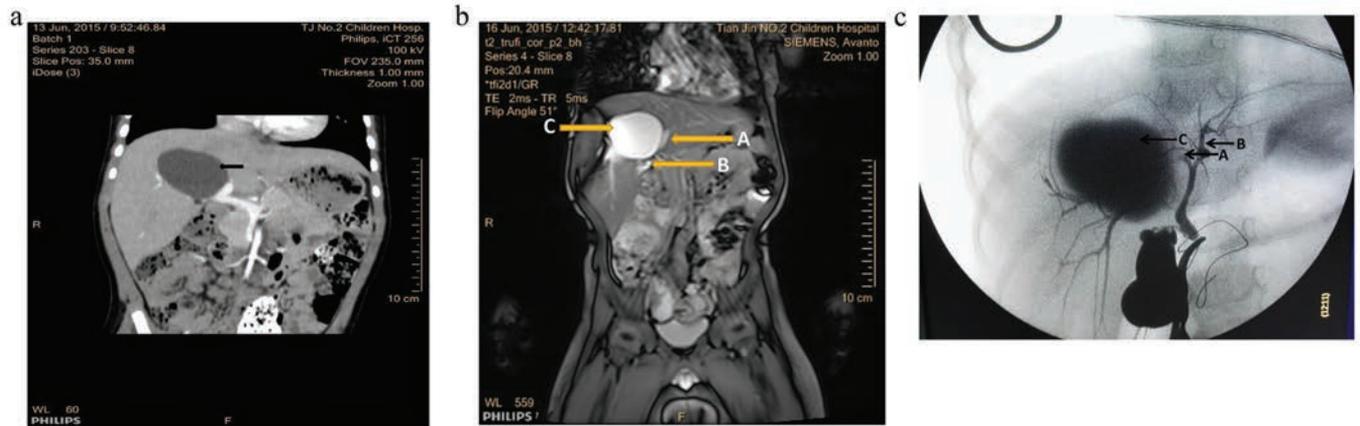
a: CT scan (arrow) shows cystic mass in the right hepatic lobe, the mass boundary is irregular, the size is about 54.1 * 48.6 mm, extending to the hepatic hilar region. Fig. 1b: MRI showing an irregular mass in the right hepatic lobe, which is about 5.1_4.6_4.3 cm, the border is clear. Adjacent intrahepatic duct is lightly pressed, the mass extending to the hepatic hilar region and has close relationship with intrahepatic bile duct. (A. left hepatic duct, B. right hepatic duct, C.cyst). Fig. 1c. Intraoperative cholangiogram showing the cyst is communicated with intrahepatic bile duct. (A. right hepatic duct, B. left hepatic duct, C. cyst).
